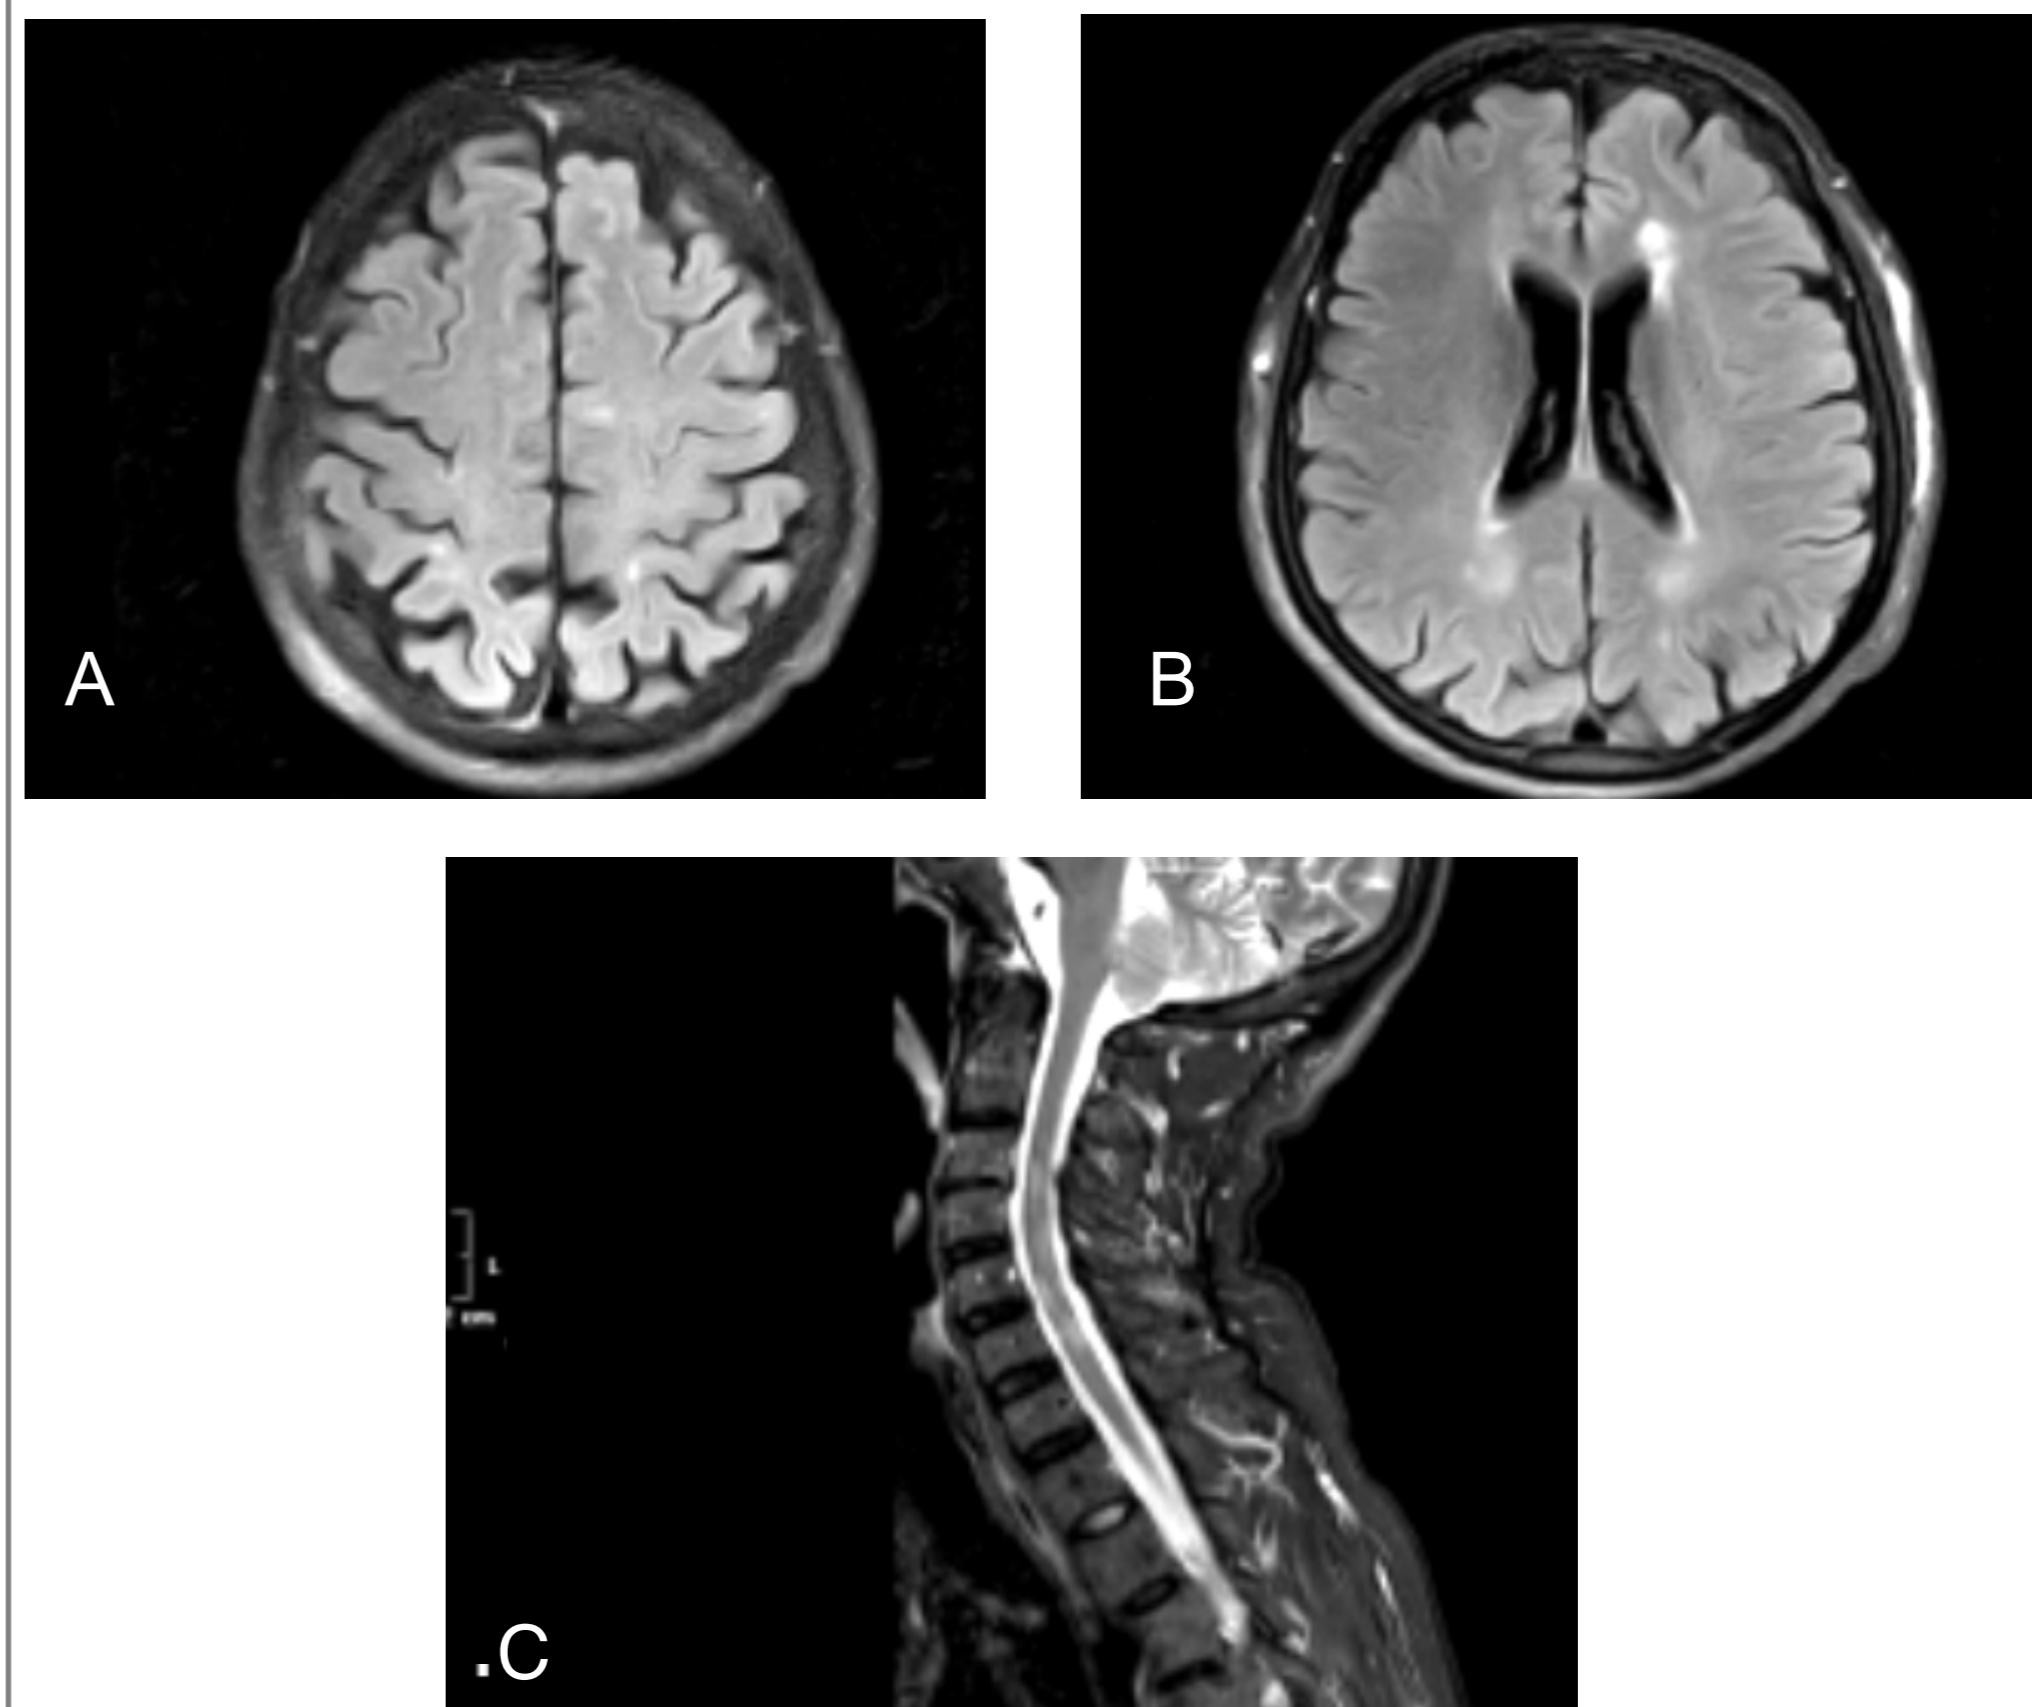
a-c. Axial fluid attenuation inversion recovery (FLAIR) images (3T) (a-b) showing bilateral areas of hyperintensity suggestive of demyelinating lesions in the juxtacortical and periventricular regions. Short T1 inversion recovery (STIR) image (c) revealed multiple demyelinating lesions in the cervical cord
